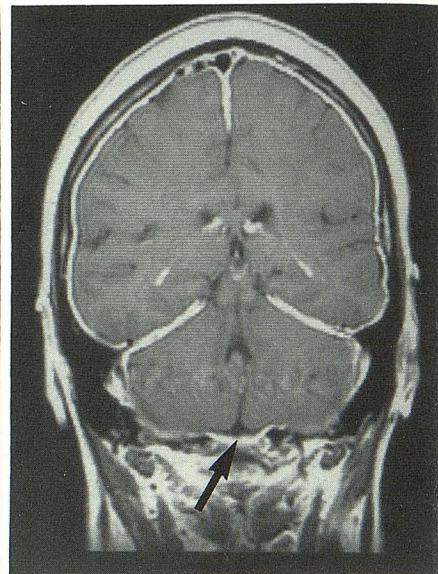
Coronal T1-weighted (600/20) gadopentetate-dimeglumine-enhanced MR image corresponding to Figure 1 shows diffuse enhancement of meninges. The abnormality is better demonstrated by contrast MR than by non-contrast MR (Figs. 1 and 2). Note enhancement near base of craniovertebral junction (arrow).
